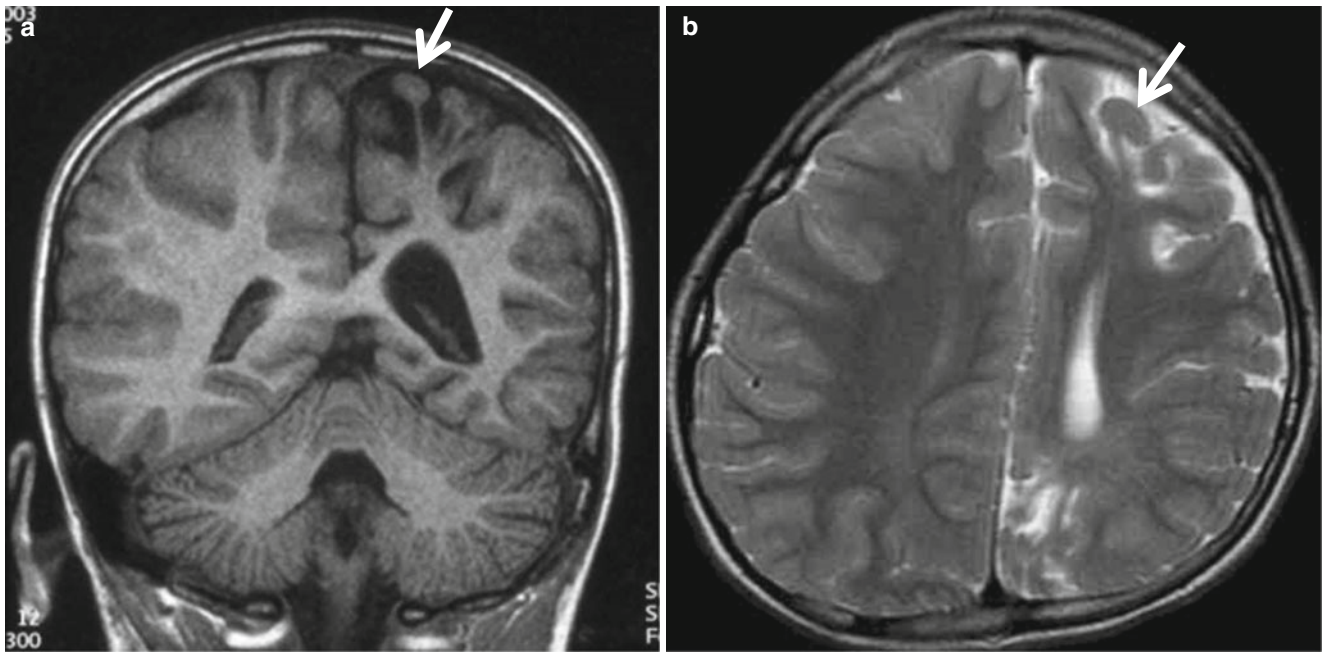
Ulegyria in chronic watershed injury. T1-weighted coronal (a) and T2-weighted axial (b) images show more tissue loss at the depth of sulci than the superficial portion of the cortex resulting in mushroom-shaped gyri (*arrow*)
